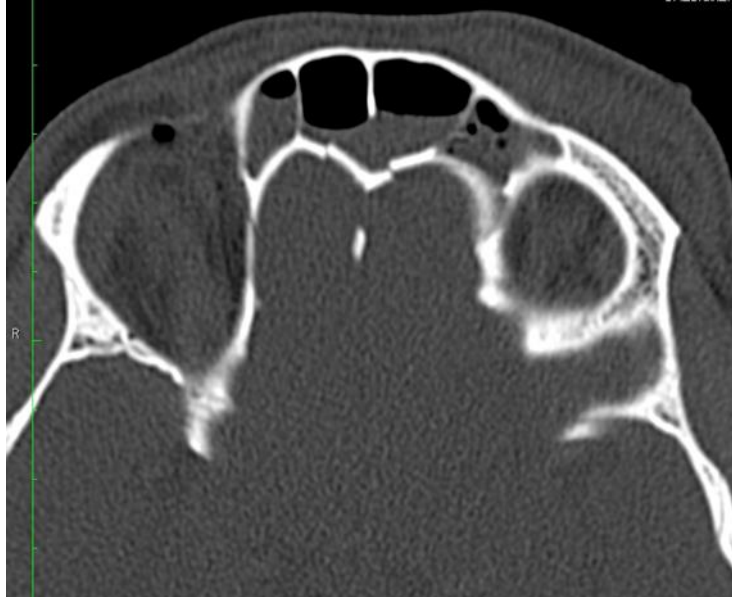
Axial CT image of the orbits shows an undisplaced fracture through the medial wall of the right orbit. Also seen are fractures through the posterior walls of the frontal sinuses with hemosinus.
